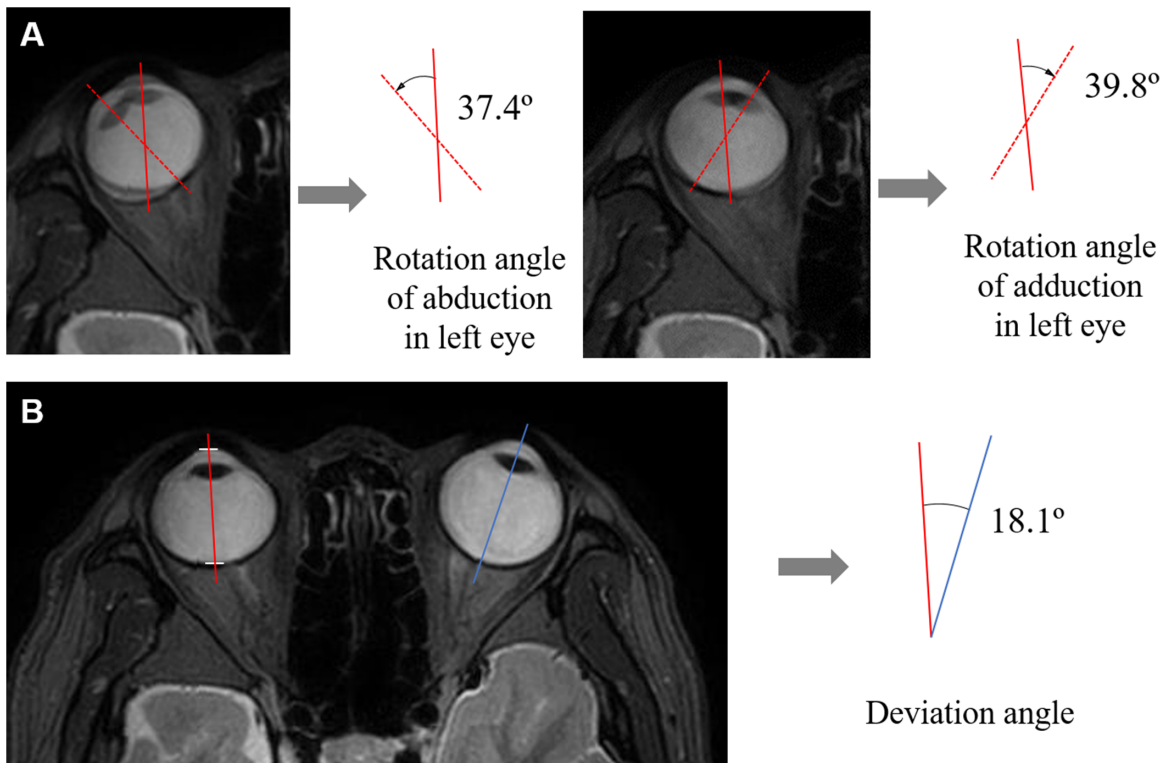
Various measurements in MR images. (A) In the superimposed MR image, the visual axes of the left eye are marked with red lines; the solid lines indicate the visual axes in the central gaze, and the dotted lines indicate the visual axis in lateral gazes. The visual axis was defined as a perpendicular line to the lens connecting the corneal vertex and fovea. The angle between two visual axes is the rotation angle of abduction (up) and adduction (down). (B) Deviation angle is the angle between visual axes of both eyes (the *red line* in the fixating eye and the *blue line* in the deviating eye) in MR images in which the study eye (left eye in this case) is fixated at the central target. The axial length was also measured as the distance between two short white lines, which indicate the corneal vertex and the fovea on the visual axis when the eye was fixated at the central target.
